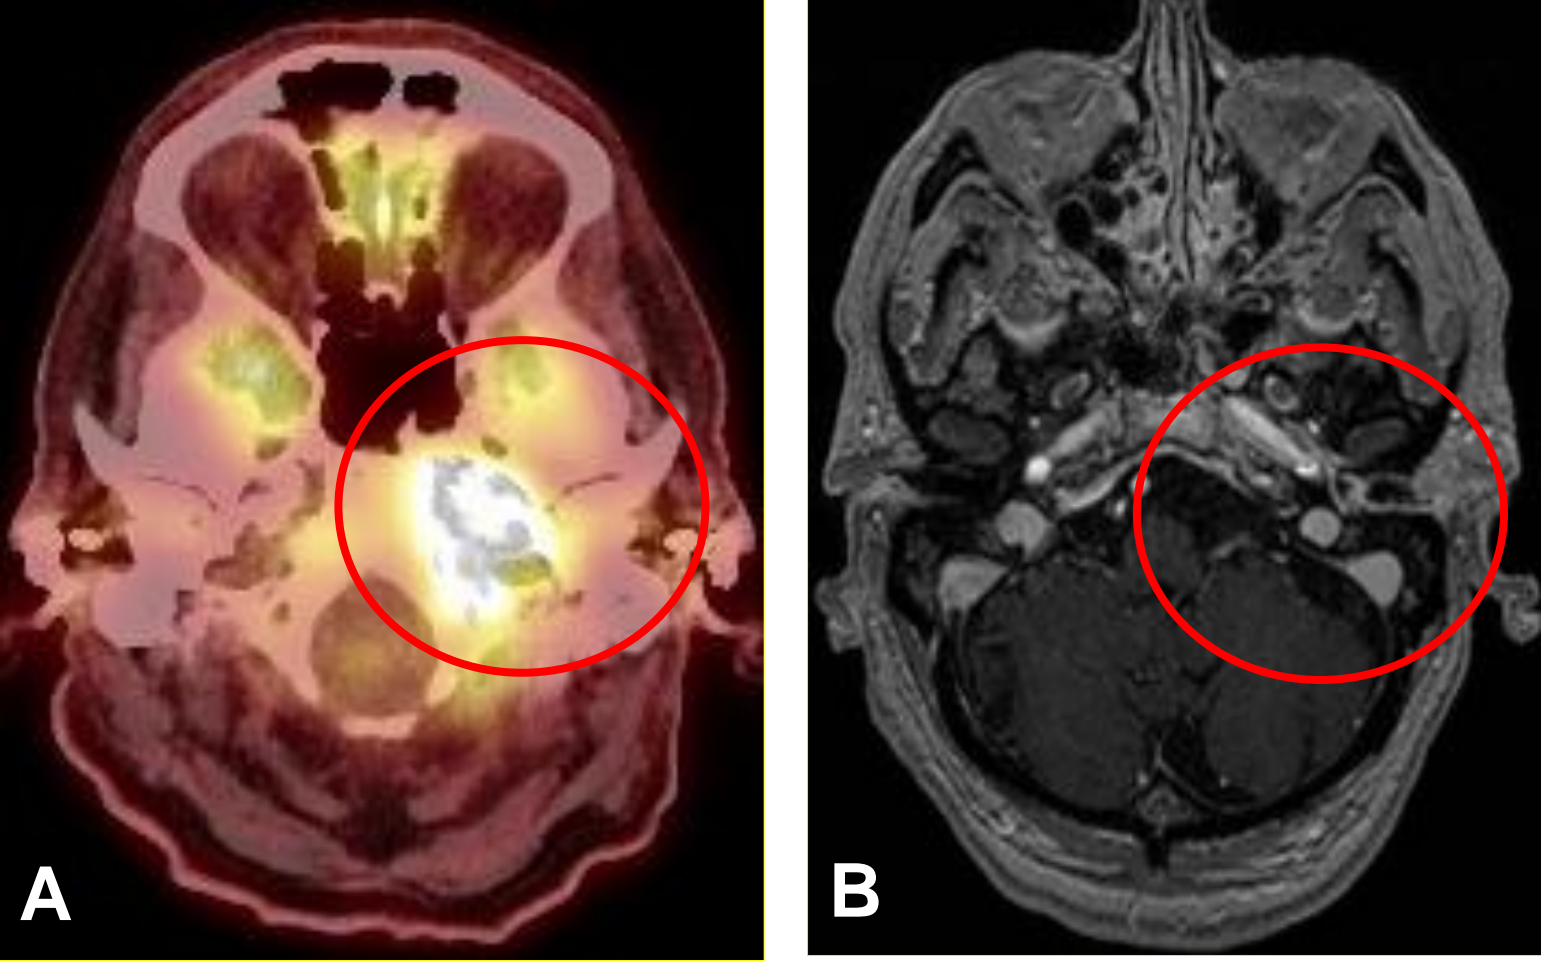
A, Axial PET-CT, B, Axial 3T MRI T1, C Axial 3T MRI T2 post gadolinium, D Axial 3T MRI STIR patient with Diabetes Mellitus & Necrotizing Otitis with false positive PET-CT with increased uptake in left mastoid, left petrous apex and left skull base. Axial T1 MRI with gadolinium enhancement, T2 with soft tissue swelling external auditory canal, fluid filled Eustachian tube, opacified left mastoid, middle ear with sinus opacification.
